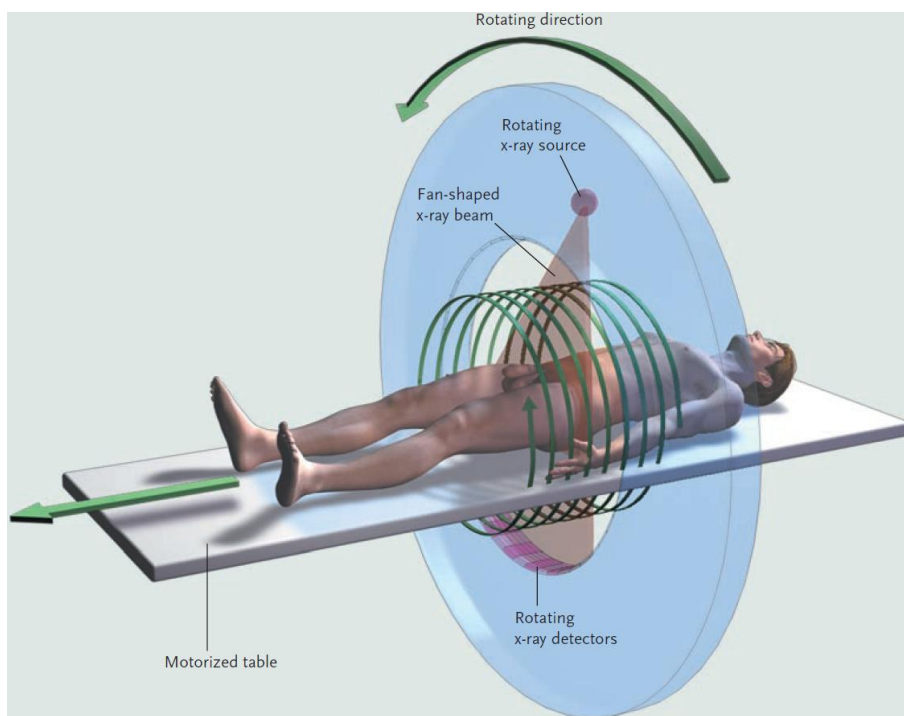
Principle of the helical CT, with an x-ray source on one side and x-ray sensors on the other side. Both rotate simultaneously while the patient's bed is displaced. Image reproduced from [40] with permission from the Publishing division of the Massachusetts Medical Society.
